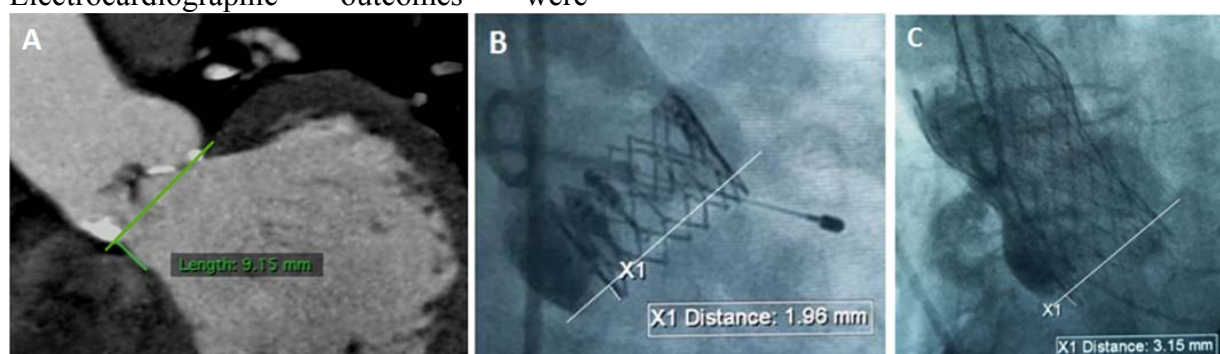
(A) CT coronal view showing measurement of membranous septum length, (B and C) Fluoroscopy views showing measurement of depth of implantation of Sapien XT and Evolut R valves respectively.
